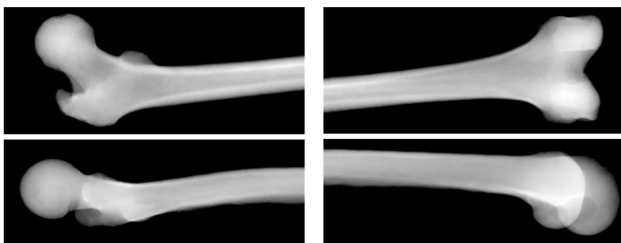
The sample test case. Two pairs of orthogonal radiographs capturing the proximal (left) and the distal (right) part of the virtually fractured femoral bone
